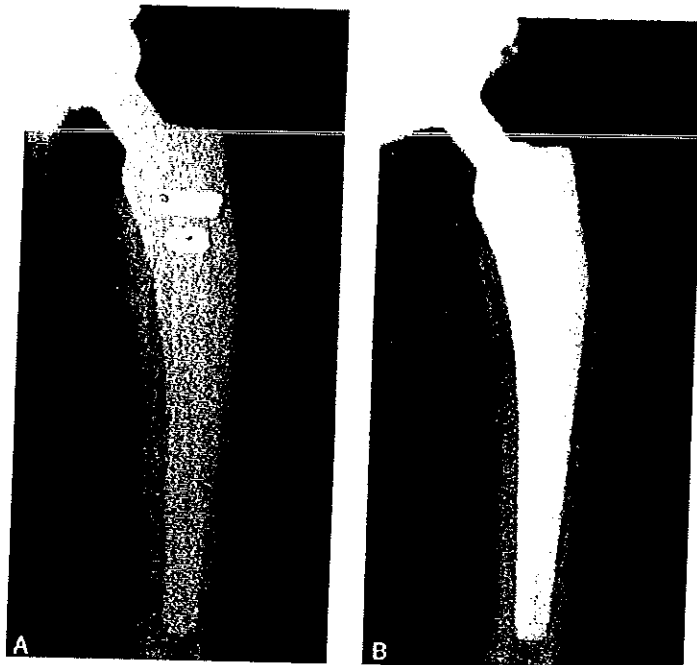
(A) Anteroposterior radiograph of a 32-year-old woman shortly after surgery. (B) At 13 years, the femoral component remains well fixed and without osteolysis.
